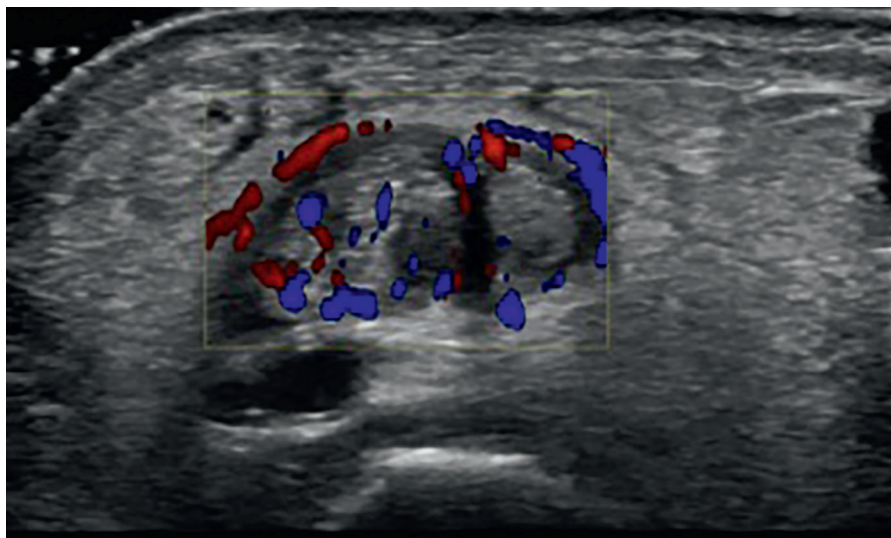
Ultrasound demonstrating de Quervain's tenosynovitis, with thickening of the abductor pollicis longus tendon, excess fluid, and increased vascularity within the tendon sheath.
